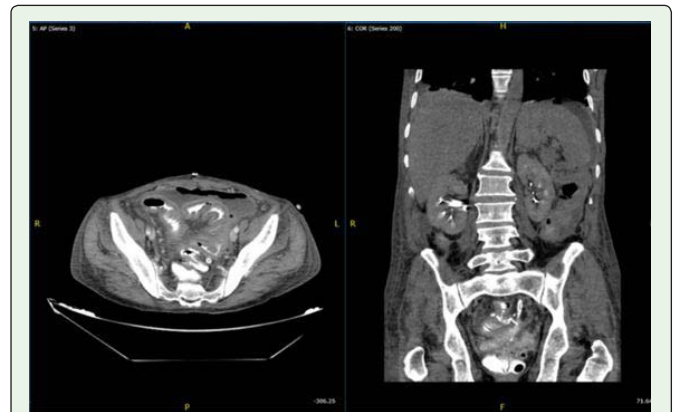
Pelvic computed tomography scan showed anastomotic leak with a large amount of free fluid and pneumoperitoneum.
